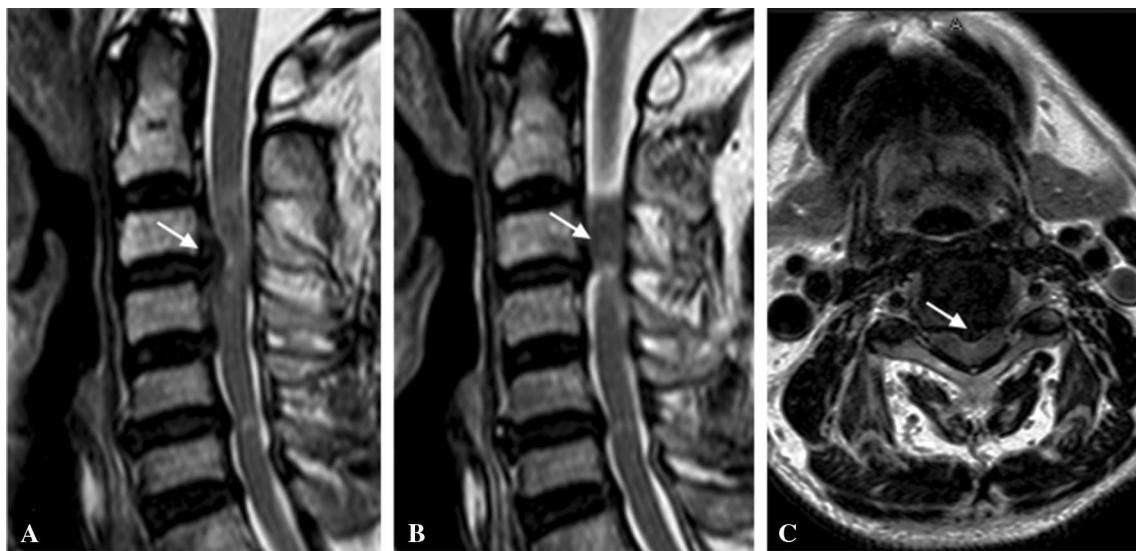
T2-weighted sagittal image (a) revealed C3/4 disc herniation, with dural sac and spinal cord compression. There are heterogeneous signals in the context of spinal cord. One slice apart, behind C3 vertebra it seemed that there was an isolated mass with isointense signal
